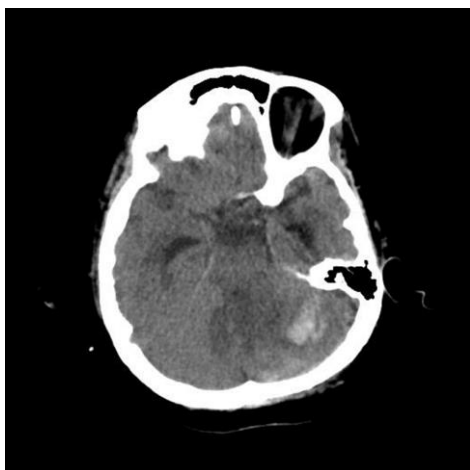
CT scan axial image showing hemorrhage in left cerebellar hemisphere in similar patient shown in figure 2.
